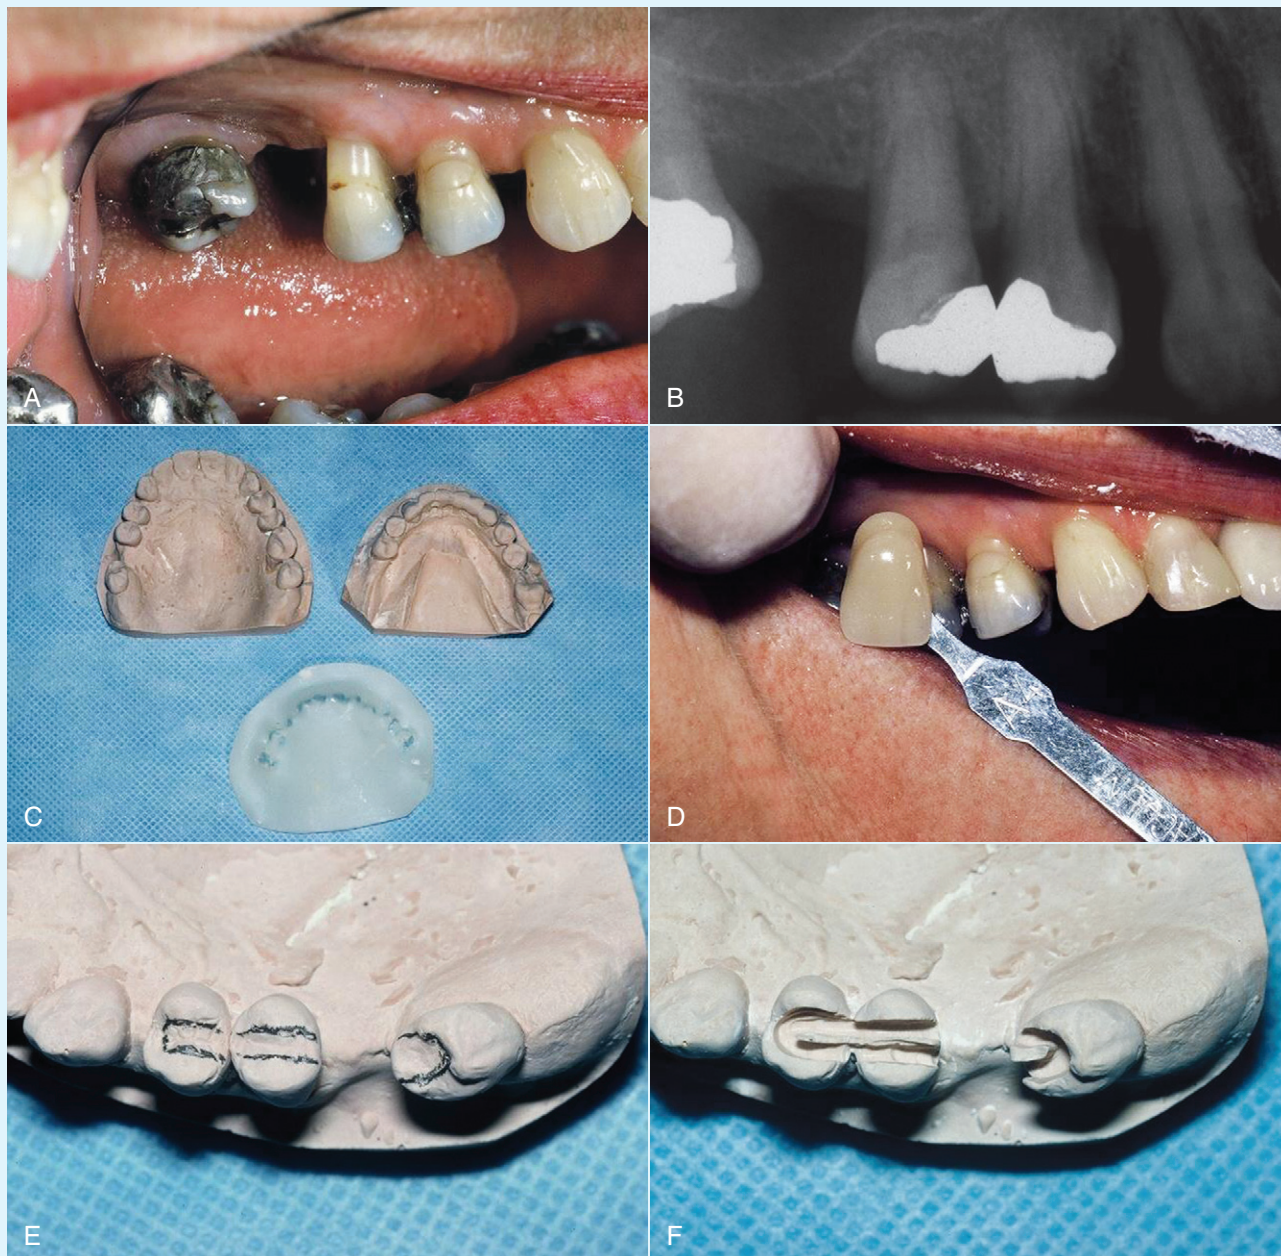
Pre-treatment clinical photo (A) and radiograph (B) show the first and second bicusps with areas of gingival recession, cervical erosion, and previously placed restorations with decay on their facial surfaces. They are un-esthetically “long” in appearance. The upper right first molar tooth is missing and the second molar heavily restored with amalgam. C, Alginate impression stone model of the arch to be restored (*top left*), counter-impression for indirect laboratory fabrication of the transitional bridge (*top right*), and bite registration (*bottom*). D, Shade guide used to select correct color for the pontic. E, Location of the attachments marked on the model with a pencil. F, Abutment teeth prepared on the model for fiber reinforcement.
